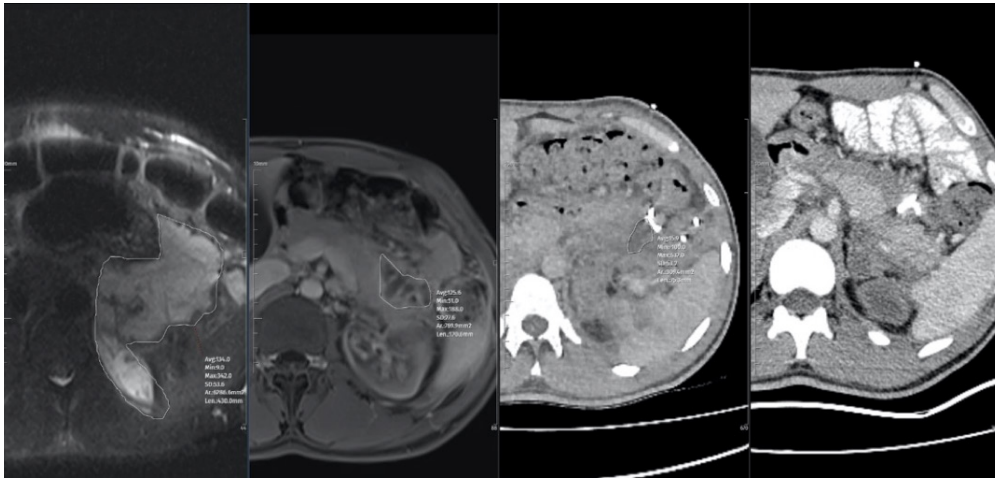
Imaging findings of a pancreatic fistula-associated loculated cystic fluid collection. On fat-suppressed T2-weighted magnetic resonance imaging (MRI), the collection appears hyperintense. Following placement of a drainage catheter, contrast-enhanced fat-suppressed T1-weighted MRI demonstrates a reduction in the size of the rim-enhancing loculated collection. Subsequent serial follow-up contrast-enhanced abdominal computed tomography (CT) scans (third and fourth images) show further decrease in the size of the collection, with complete regression in the final image. The drainage catheter is visible as a hyperdense tubular structure on CT.
